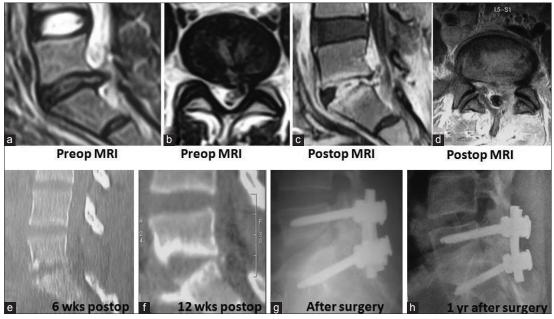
MRI scans of patient with postoperative discitis – preoperative T2-weighted sagittal and axial views (a,b) showing L5/S1 (L) sided disc prolapsed. Postoperative T1-weighed sagittal (c) and axial views (d) postoperative infective changes in the disc space with evidence of decompression. Sagittal reconstruction CT scan (e) showing endplate changes and erosion due to increased vascularity and granulation tissue (6 weeks) and at 12 weeks (f) shows sclerotic changes in endplates along with increased destruction. Immediate (g) and 1 year postoperative lateral skiagram (h) after transpedicular fixation showing spontaneous fusion in the vertebral bodies (L5/S1)
